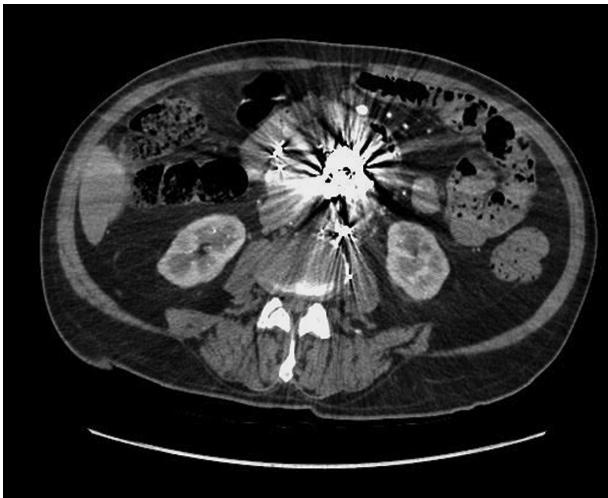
Computed tomography scan of the embolization material and endocoils inside the aneurysm sac.
